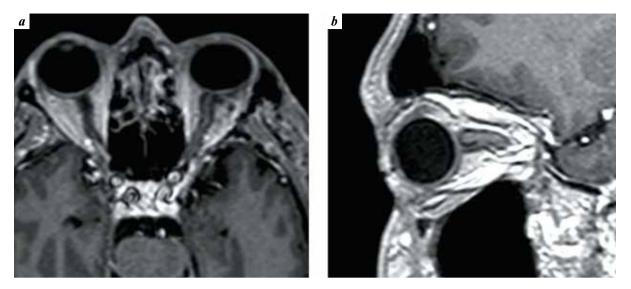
Contrast-enhanced T1-weighted magnetic resonance imaging of the patient T. in 6 months after surgery. Images show the straightened left optic nerve after total removal of the orbital cavernous hemangioma: a - axial view; b - sagittal view
